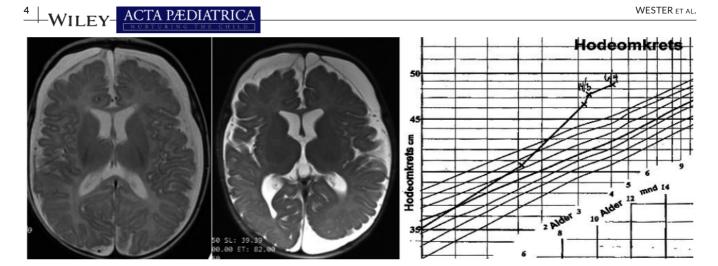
Patient #13. T2-weighted MRI at 2.5 months shows bilateral subdural hygroma or chronic SDH. There is no compression of underlying gyri and clearly visible subarachnoid space, suggesting an underlying BEH. MRI at 4 months (middle) shows slight increase in volume of subdural fluid, with compression of cerebral gyri. Right: HC growth curve showing a gradual increase over several weeks. 'Hodeomkrets': head circumference, 'Alder': age in months
